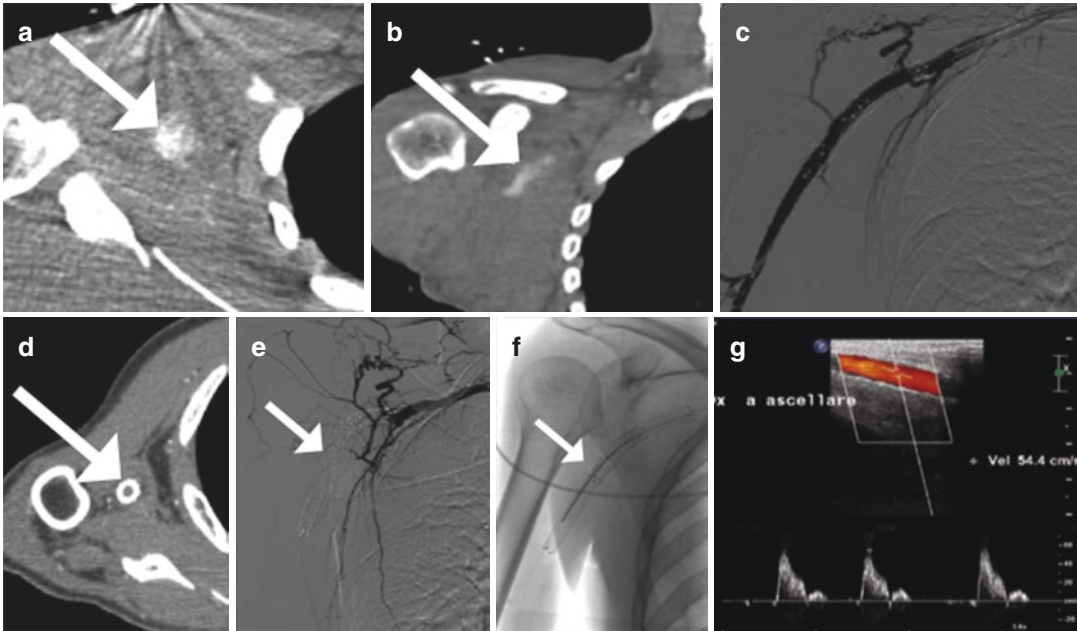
CTA (axial (a) and coronal (b)) reveals an active bleeding (*arrow*) resulting by a transection of axillary artery; angiogram performed after deployment of three imbricated covered stents (c); 6 months later, CTA
